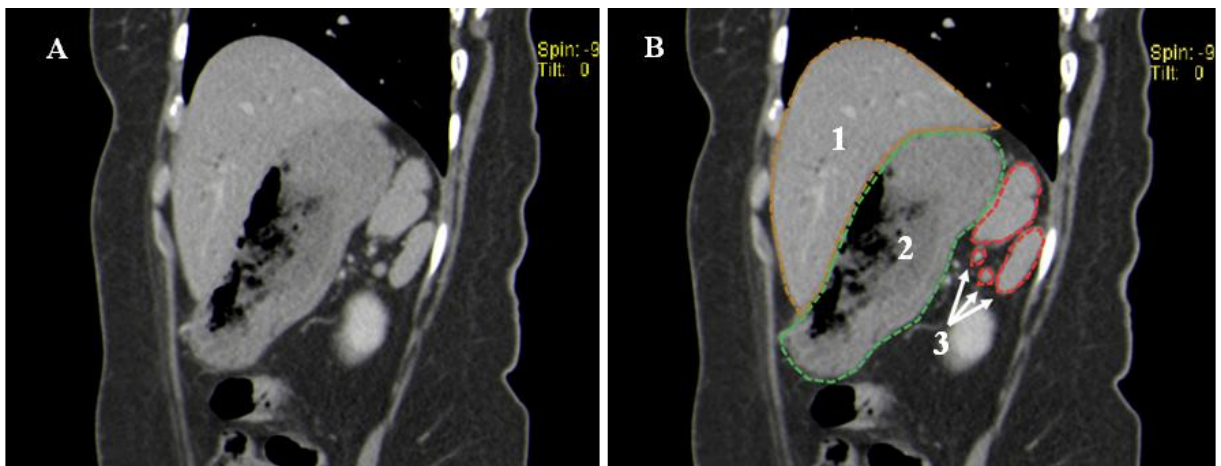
A. CT scan of the whole abdomen with IV and oral contrast (sagittal section). B. Sagittal section labeled as follows: (1) liver, (2) stomach, (3) spleen with multiple splenules.
